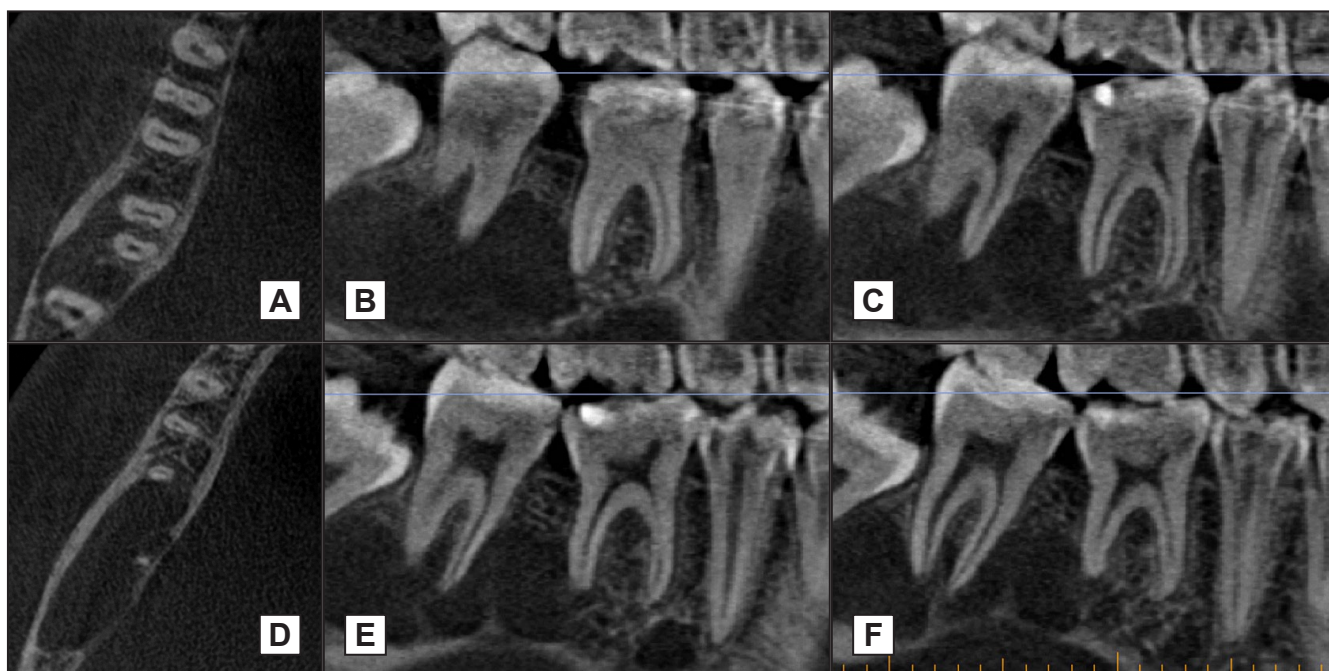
Cone-beam computed tomography axial (A and D) and sagittal (B, C, E, F) planes - large periapical lesion surrounding the right mandibular third and second molars, distal root of the first molar and extending below the second premolar. Size of the lesion: 10.4 mm in buccolingual direction, 15.1 mm in height, and 53.5 mm in mesiodistal direction (10.4 × 15.1 × 53.5 mm).
